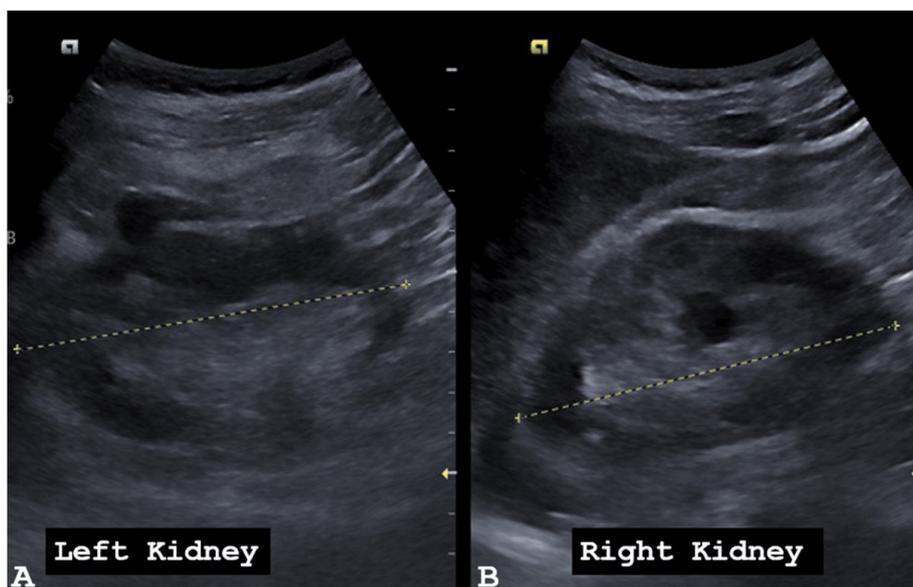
Bilateral Kidney Ultrasound. Bipolar kidney diameter (left kidney 10.66 cm, right kidney 10.68 cm).
